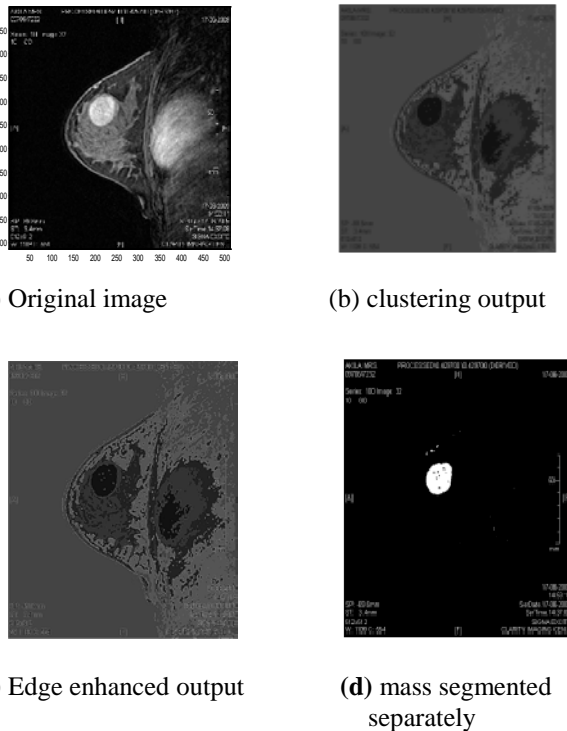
A representative original breast image with tumor obtained from 1.5Telsa MRI and the corresponding segmentation of the mass separately
